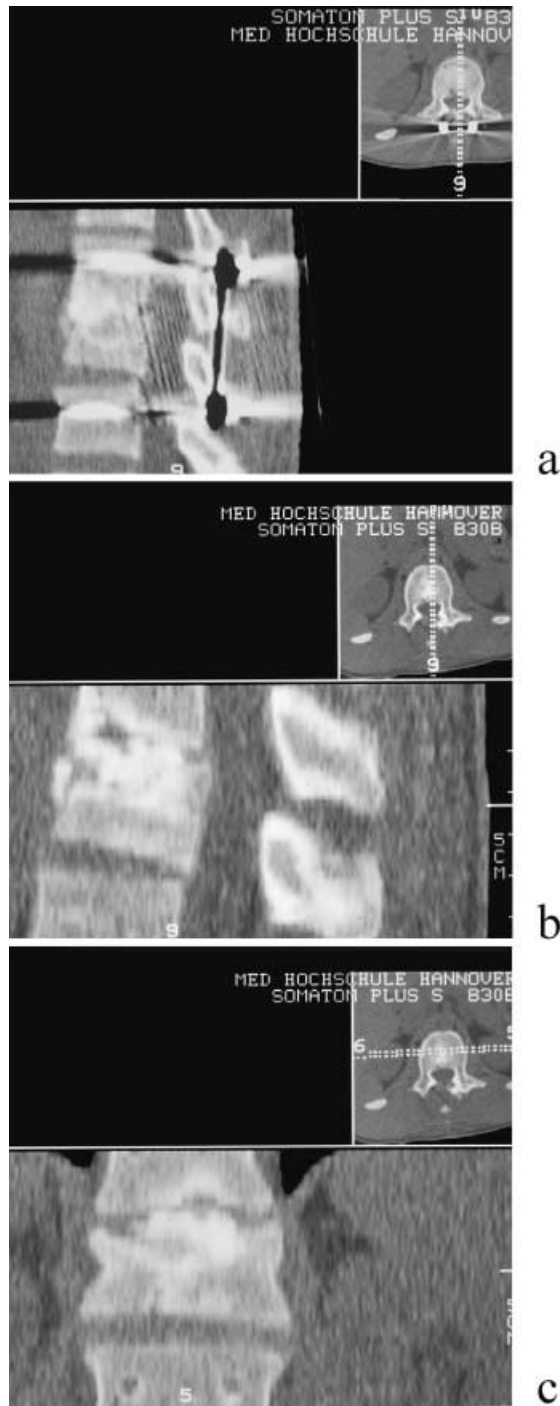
L1 split burst fracture (A3.2.1) in a 24-year-old male patient: 2D sagittal reconstruction CT scans obtained a immediately after posterior instrumentation and transpedicular bone grafting, and b,c 13 months postoperatively, following hardware removal. Absence of interbody fusion is demonstrated in the sagittal (b) and coronal (c) reconstructions. The sclerosed, unincorporated cancellous bone graft is surrounded by a zone of resorption adjacent to the vertebral body
